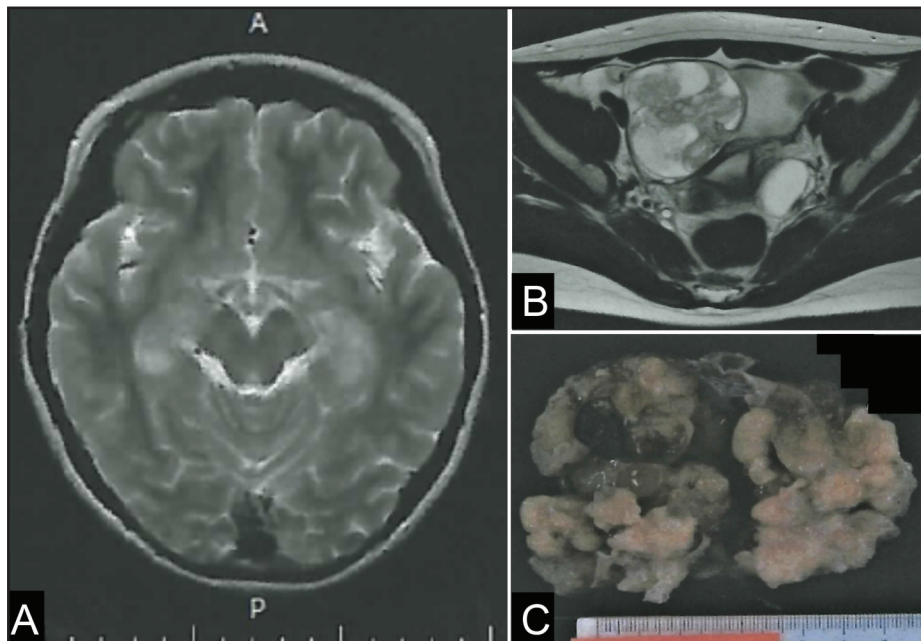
(A) Magnetic resonance fluid-attenuated inversion-recovery image at admission showing hyper intense lesions in bilateral hippocampi. (B) Abdominal magnetic resonance image showing a round tumour, 11 cm in size, with a non-uniform signal. (C) The maximum diameter of the mass is 12.0 cm.
